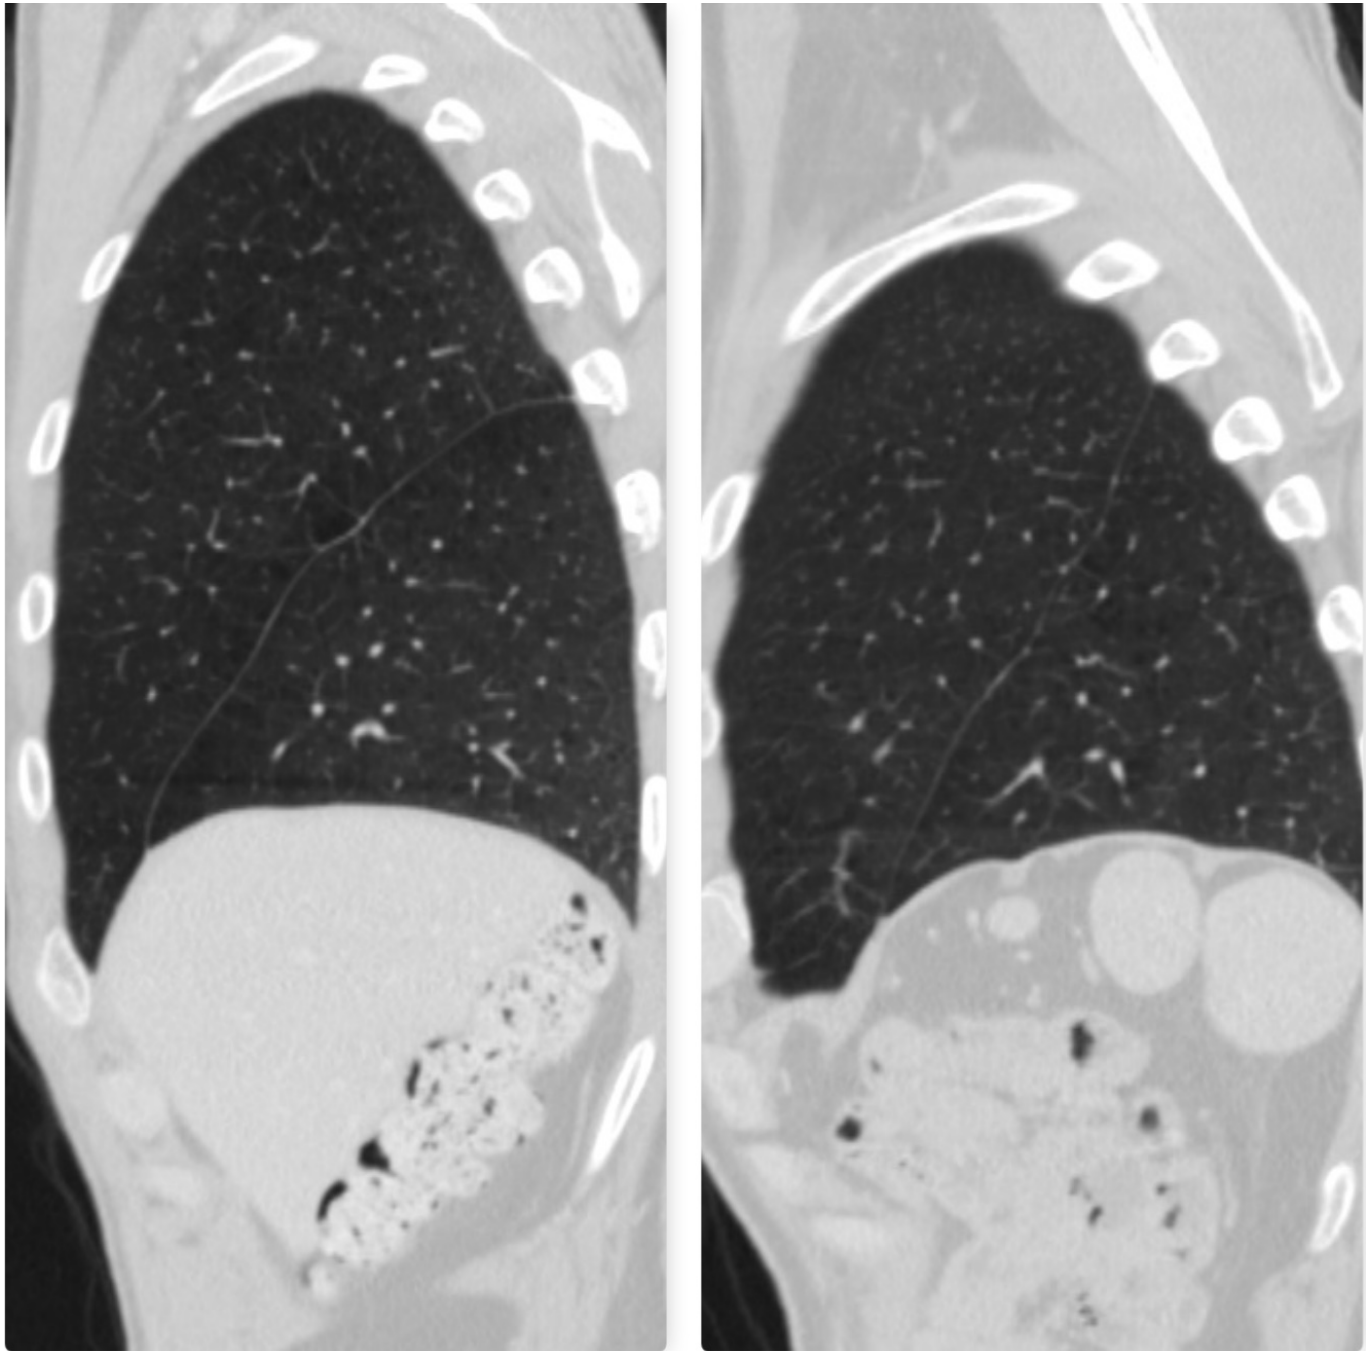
CT scan image – contrast enhanced MPR, sagittal view, lung window: on the left, the oblique fissure of the left lung, no horizontal fissure, with liver and colon visualisation below diaphragm; on the right, the oblique fissure of the right lung, with multiple spleens and jejunum below diaphragm
